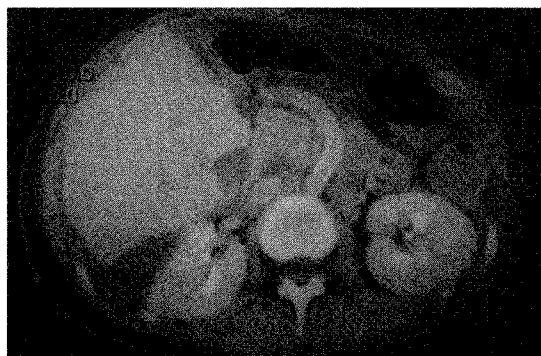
Postoperative CT scan showing the aortoportal jump graft.
